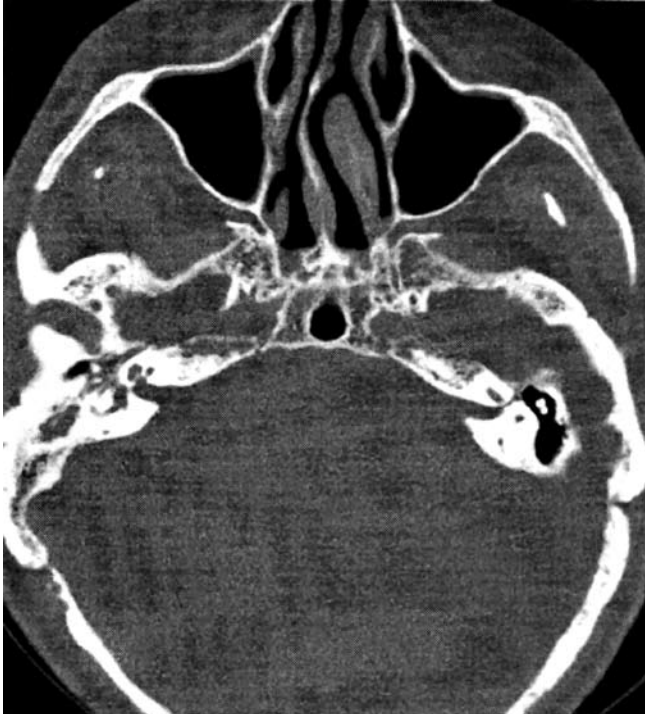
Axial CT showed a low-density mass completely occupying the mastoid and the right middle ear with no signs of erosion of the ossicular chain.
